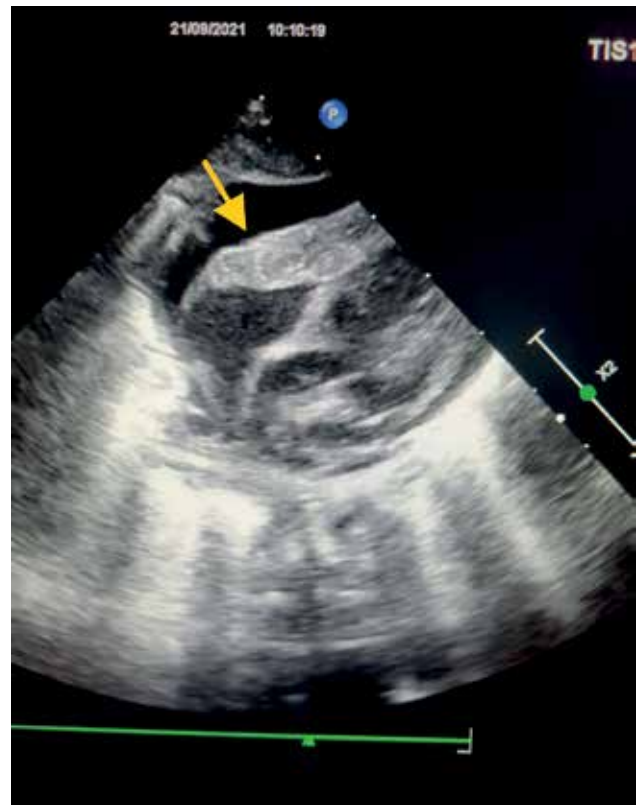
subcostal long axis view- echocardiography showing the pericardial effusion (PCE) (yellow arrow)
